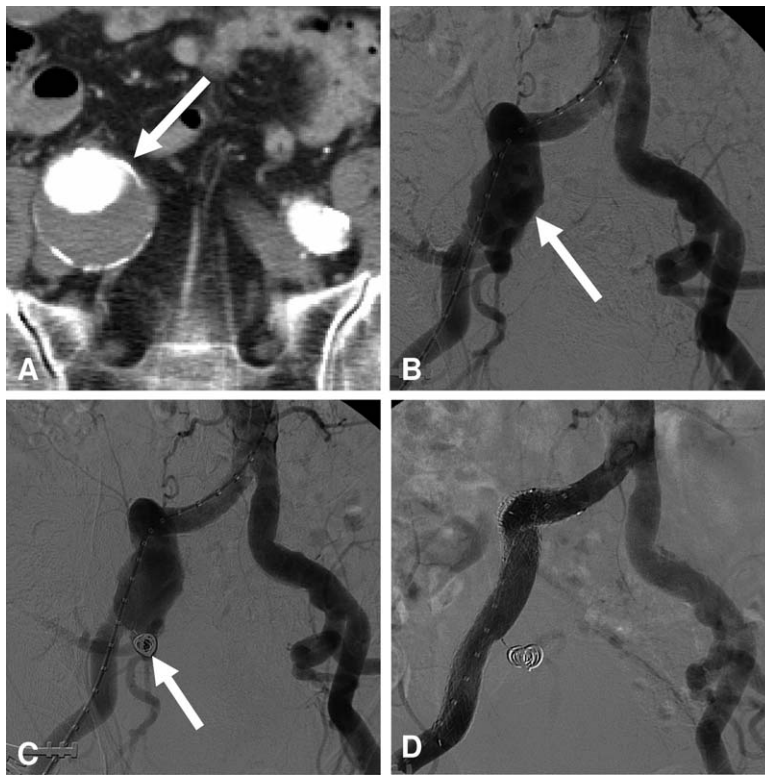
A, Preoperative computed tomography angiography of an 83-year-old patient with a 4.5-cm right common iliac artery aneurysm (arrow). B, Initial angiogram of right common iliac artery aneurysm (arrow). C, Coil embolization (arrow) of a right internal iliac artery. D, Successful exclusion of right common iliac artery aneurysm after stent-graft deployment.
